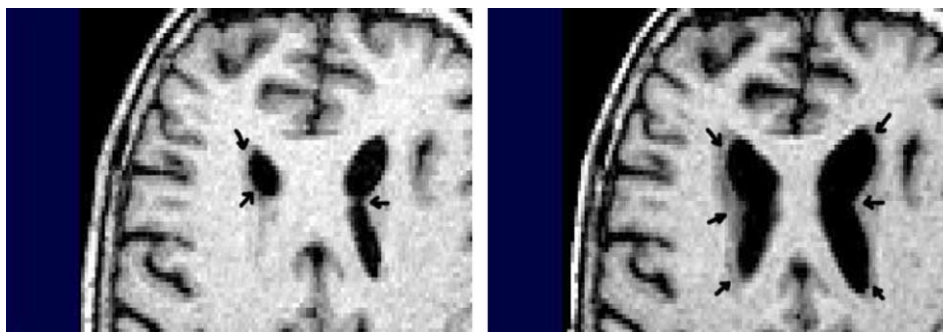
Trans-axial slices through structural MRI of a subject with Alzheimer's disease, at two different time points showing the expansion of the ventricle and growth of peri-ventricular white matter lesions (the arrows point to the lesions).
